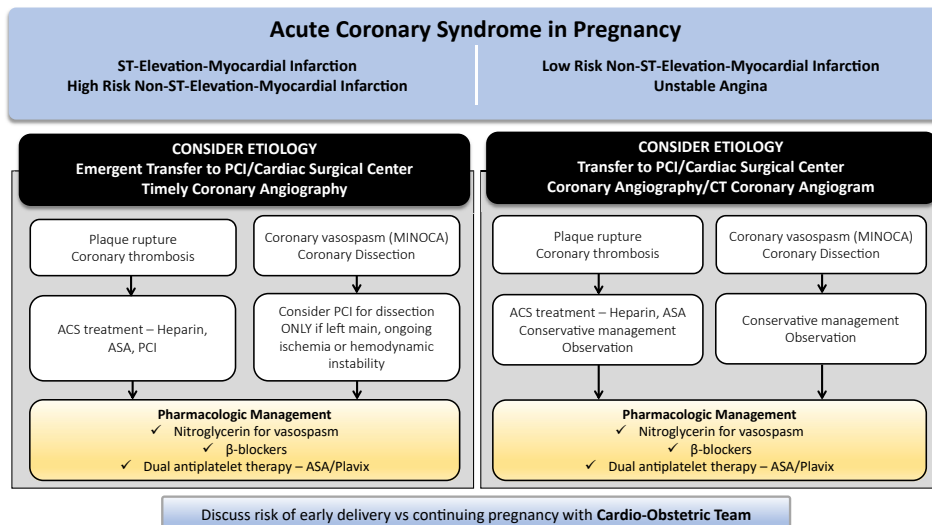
Management of ACS during pregnancy. ACS, acute coronary syndrome; ASA, acetylsalicylic acid; CT, computed tomography; MINOCA, myocardial infarction in the absence of coronary artery disease; PCI, percutaneous coronary intervention.
